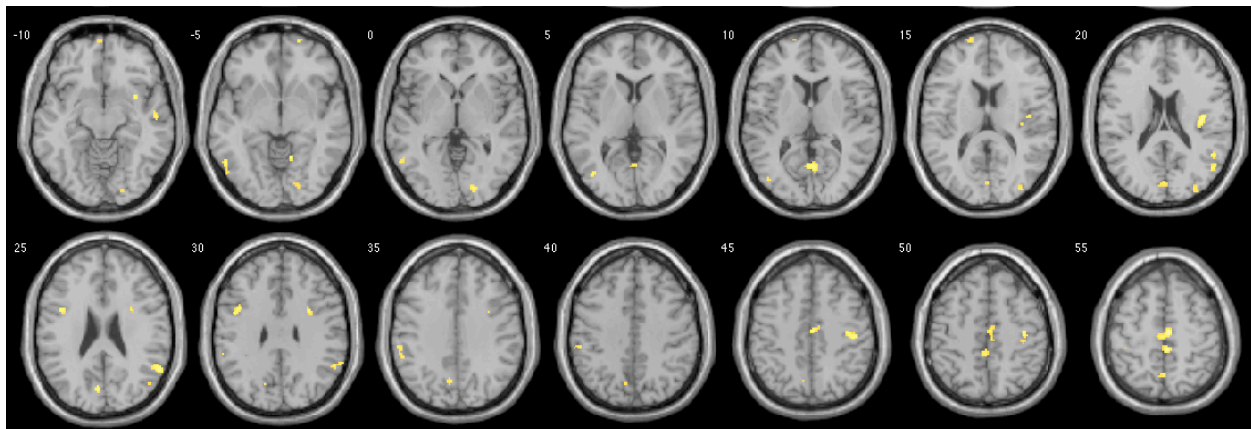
Healthy > bipolar, *decrease negative (early) > look negative* contrast. Left=Left, visualized on a canonical T1-weighted brain.
